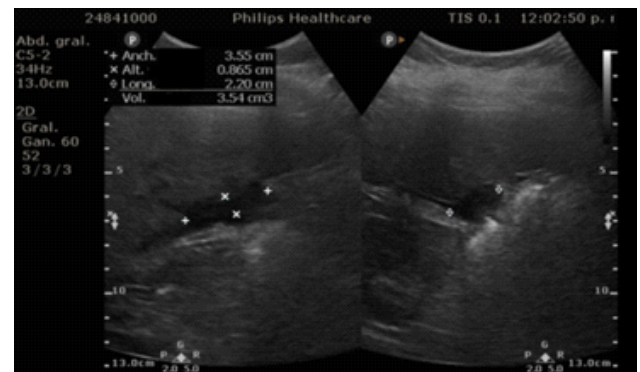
Follow-up abdominal ultrasound performed after thrombolytic administration, demonstrating near-complete resolution of the initial collection.
